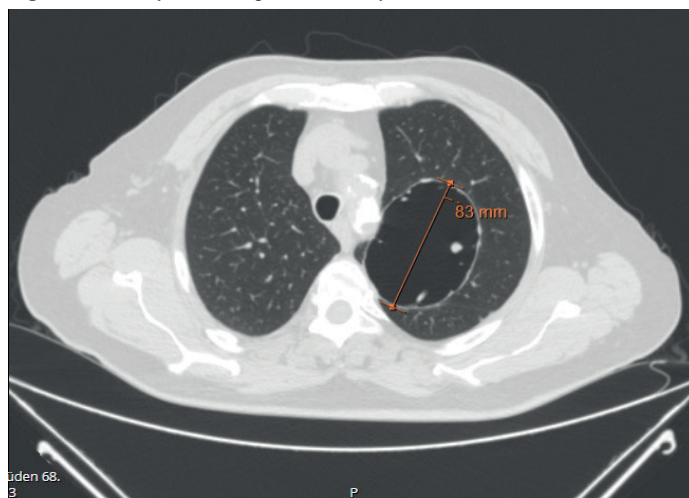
Giant cyst seen on CT
